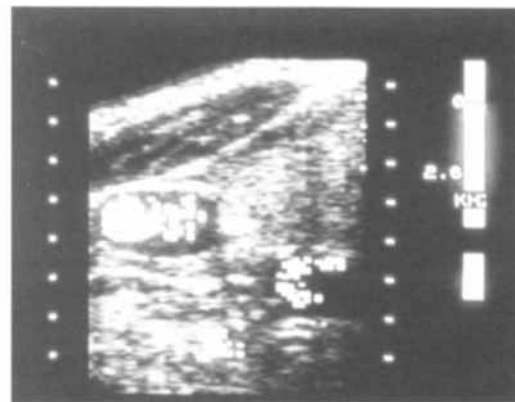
A transverse image inferior to the level of the carotid bulb reveals normal flow in the jugular vein (dark blue), and common carotid artery (red). Deep to these vessels the vertebral artery appears light blue. The color in the vertebral artery indicates flow in the direction opposite to that of the carotid artery, allowing diagnosis of reversal of vertebral artery flow associated with the subclavian steal syndrome. High Doppler sensitivity permits imaging of vessels in transverse as well as longitudinal planes, aiding in rapid identification of vessel anatomy and pathology.
